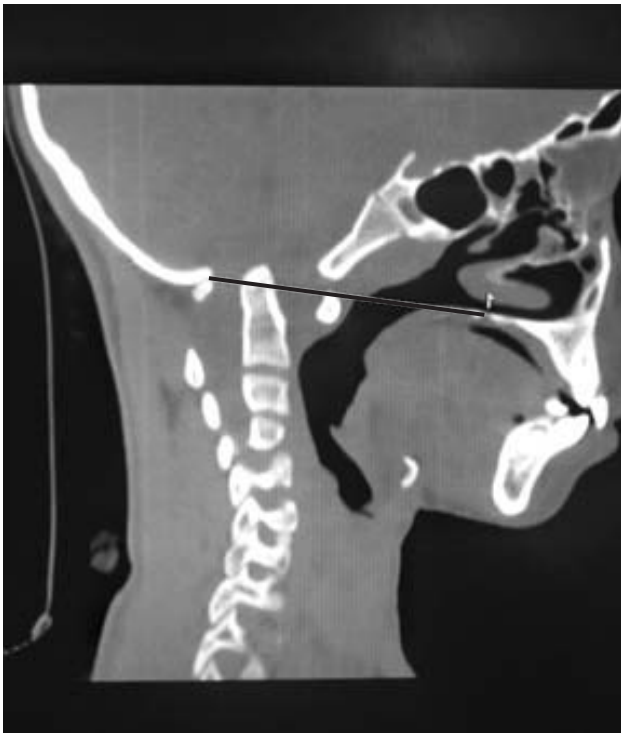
CT Sagittal reformat Odontoid process projecting above the Chamberlain line.
